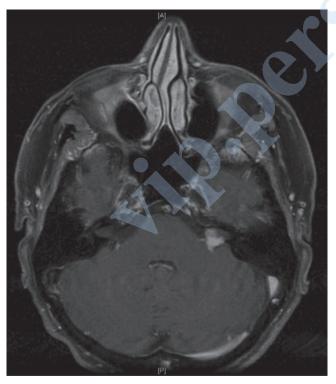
Left-sided vestibular schwannoma on contrast-enhanced TI-weighted axial MRI.
